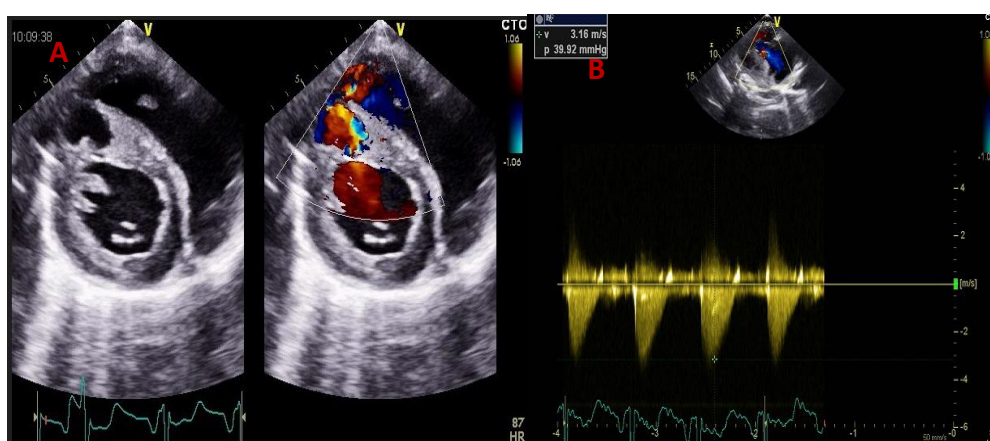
Transthoracic echocardiography : subcostal view : showing VSD defect partially closed by the pericardial wall of the RV associated with akinesia of the free wall of the RV. B- Altered systolic longitudinal function of the right ventricle with a systolique pressure of 39mmHg +10mmHg of right atrial pressure (RAP)
